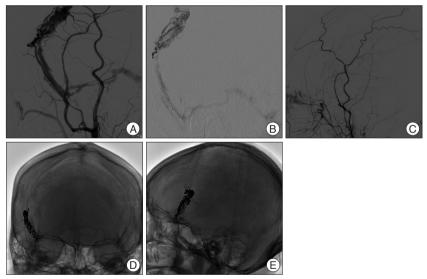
Intraoperative angiograms and skull radiographs after Onyx embolization. Magnified view (A) and superselective angiogram (B) just before Onyx injection show enlarged frontal branch of middle meningeal artery (MMA) and middle meningeal vein as well as the intraosseous dural arteriovenous fistula (DAVF). Multiple fine arterial recruitments from right MMA to fistulous venous pouch are clearly seen. Postoperative lateral view of right external carotid angiogram (C) demonstrates complete obliteration of intraosseous DAVF. Skull radiographs after Onyx embolization (D and E) show Onyx cast on the right temporoparietal area.
